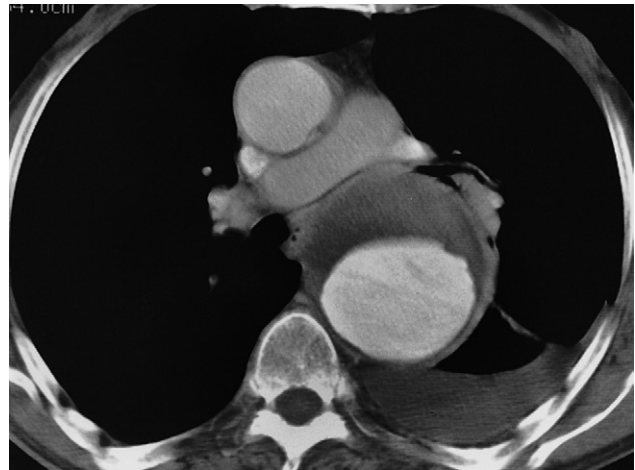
CT showing an aneurysm of the descending aorta. The lumen has been opacified by intravenous contrast enhancement. The unopacified component is clot lining the aneurysm.
